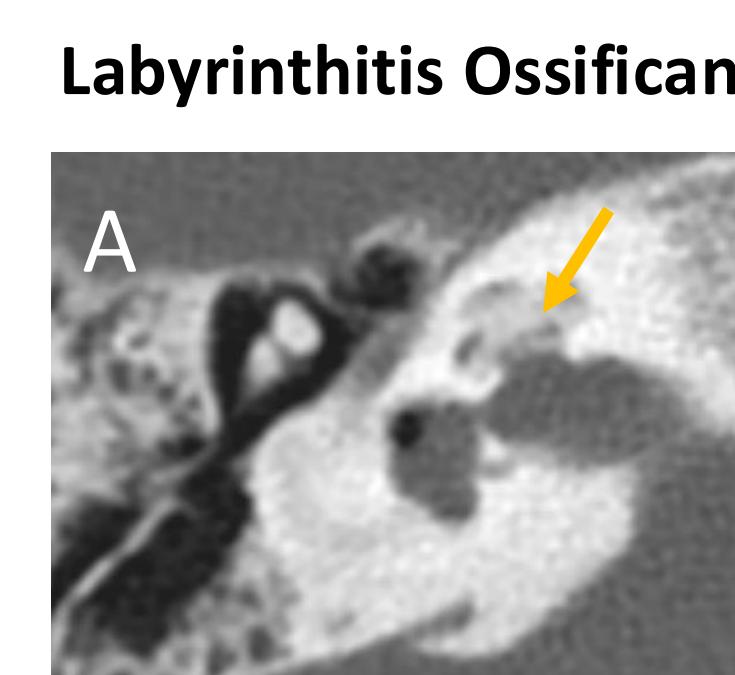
Axial CT shows extensive ossification of the cochlea (arrow) due to severe labyrinthitis ossificans.
